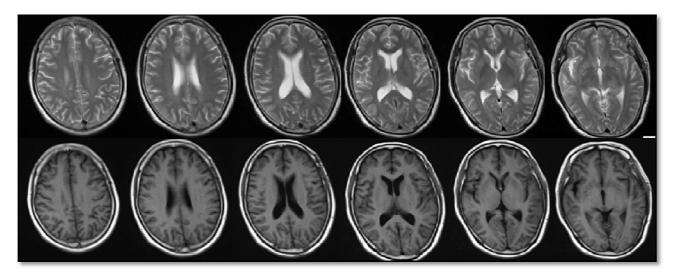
The enhanced lesions and intracranial edema disappeared in the MRI follow-up 15 days after the systematic treatment.
